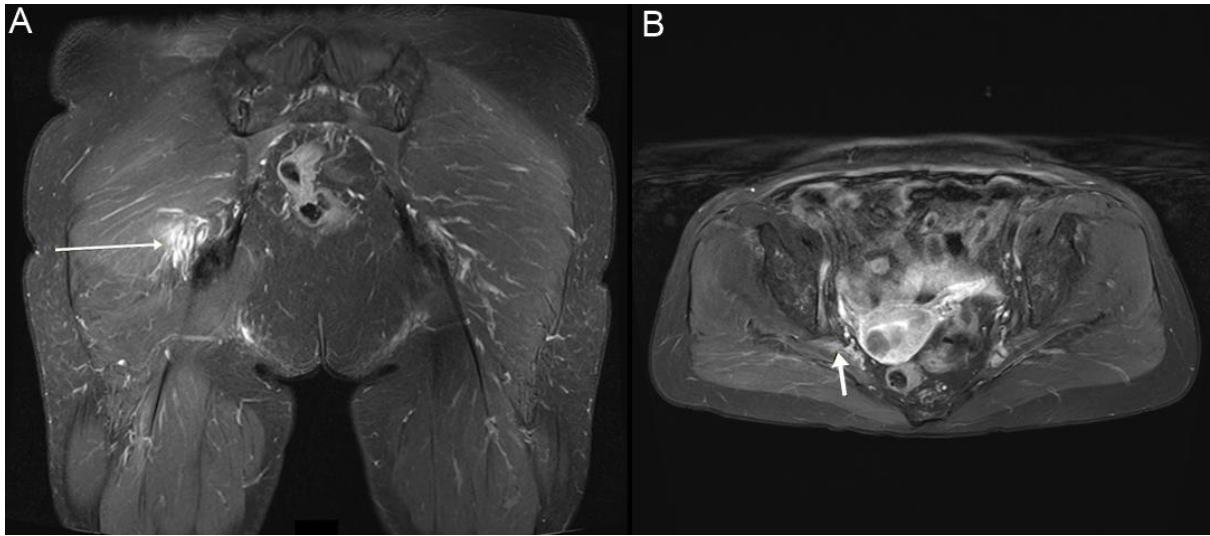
Hip MRI. (A) Coronal view, (B) axial view. Arrows: sciatic nerve.
